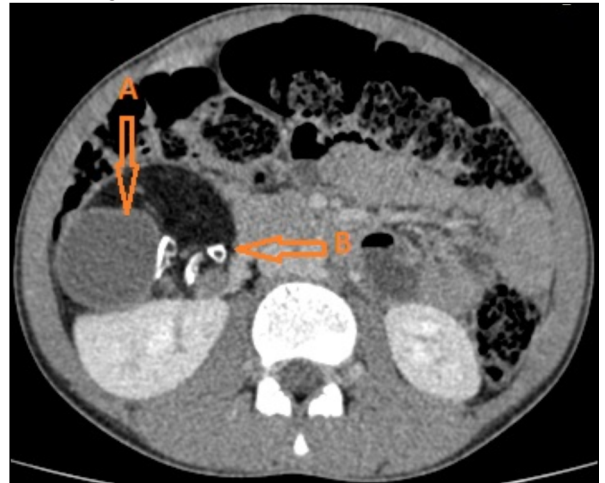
Contrast enhanced computed tomography abdomen axial shows a large heterogenous mixed density retroperitoneal SOL noted at right hypochondrium displacing right kidney inferiorly and contains (A) Deformed bony structures (B) surrounded by fat components
